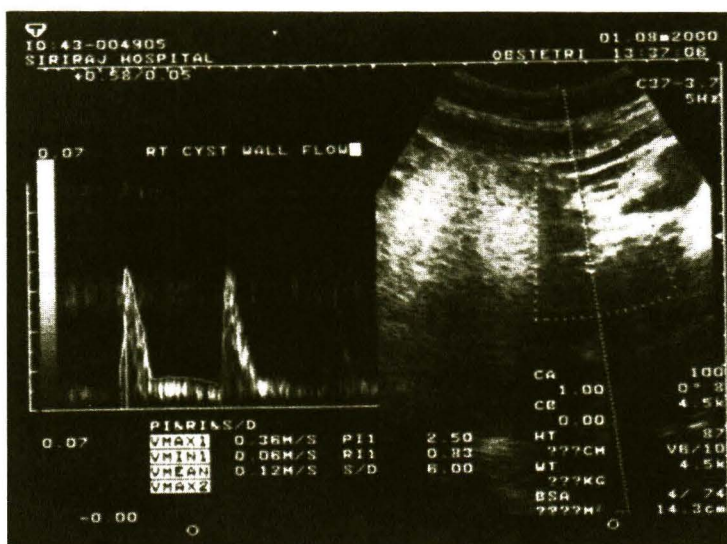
Doppler waveform of the lesion demonstrates high-impedance flow (PI = 2.5). Final diagnosis: benign cystic teratoma.
